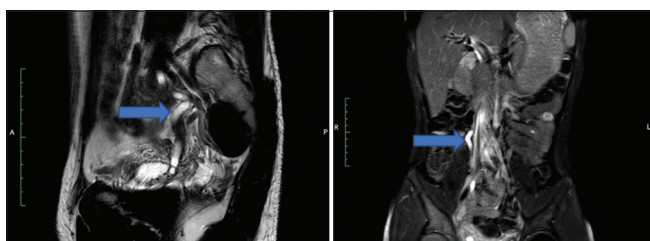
T2-weighted sagittal and a coronal image showing a moderately dilated right ureter with the lumen's upper blinding and hyperintense signals
